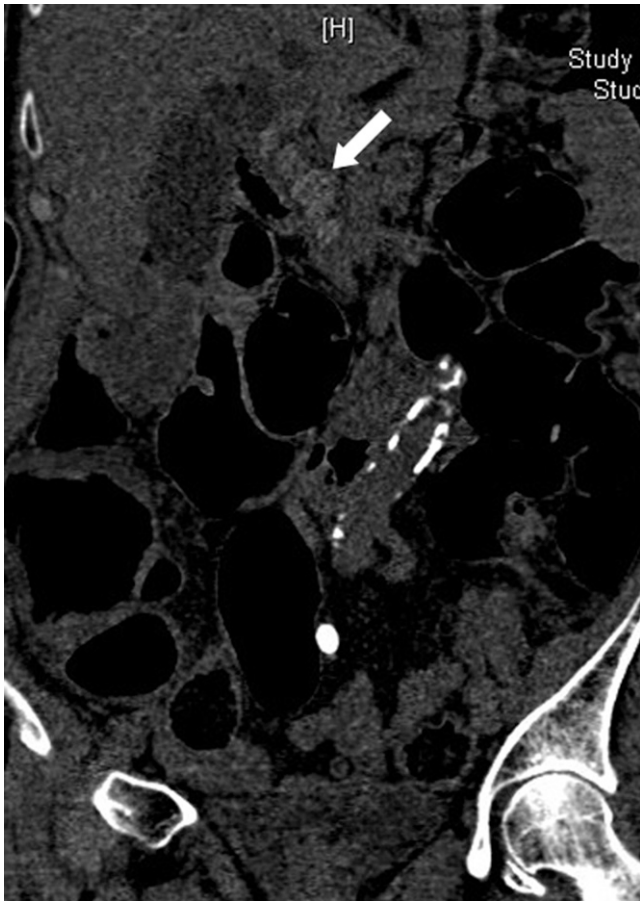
A 60-year-old woman underwent a CT pneumocolon and incidentally detected multiple calcified gallstones in the common bile duct shown on this coronal CT scan image (white arrow). Note the gallstones are best seen on the unenhanced scan.
